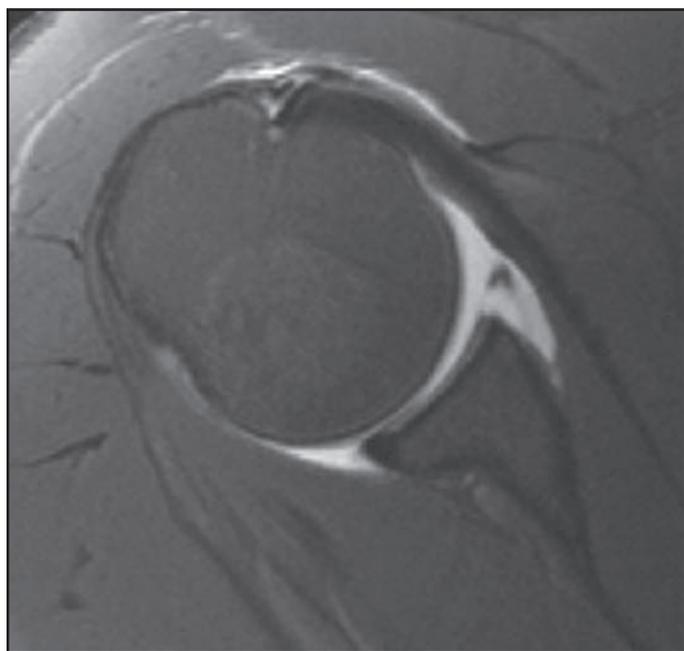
An axial slice MRI demonstrating a Bankart lesion. Notice the labral fragment at the anterior aspect of the joint line.
